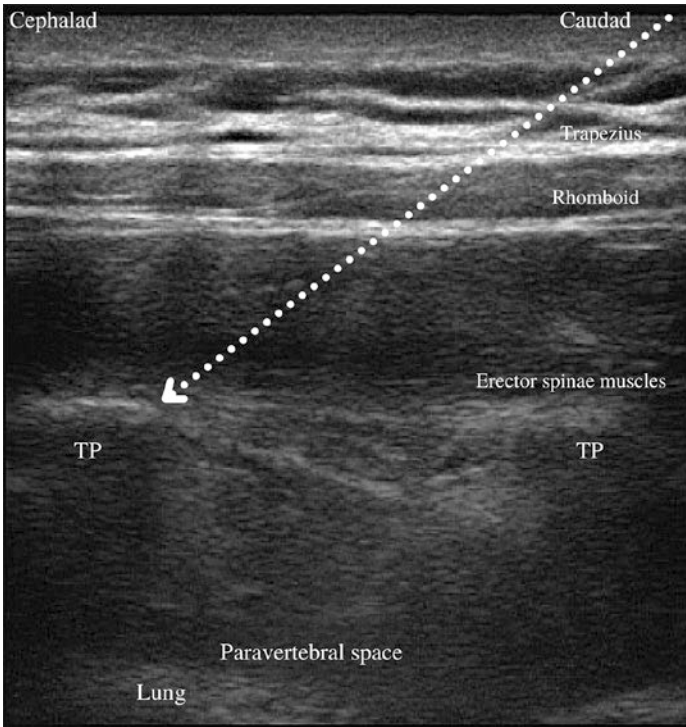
Ultrasound image of erector spinae plane block. Dotted line represents needle trajectory with arrow pointing to site of local deposition
